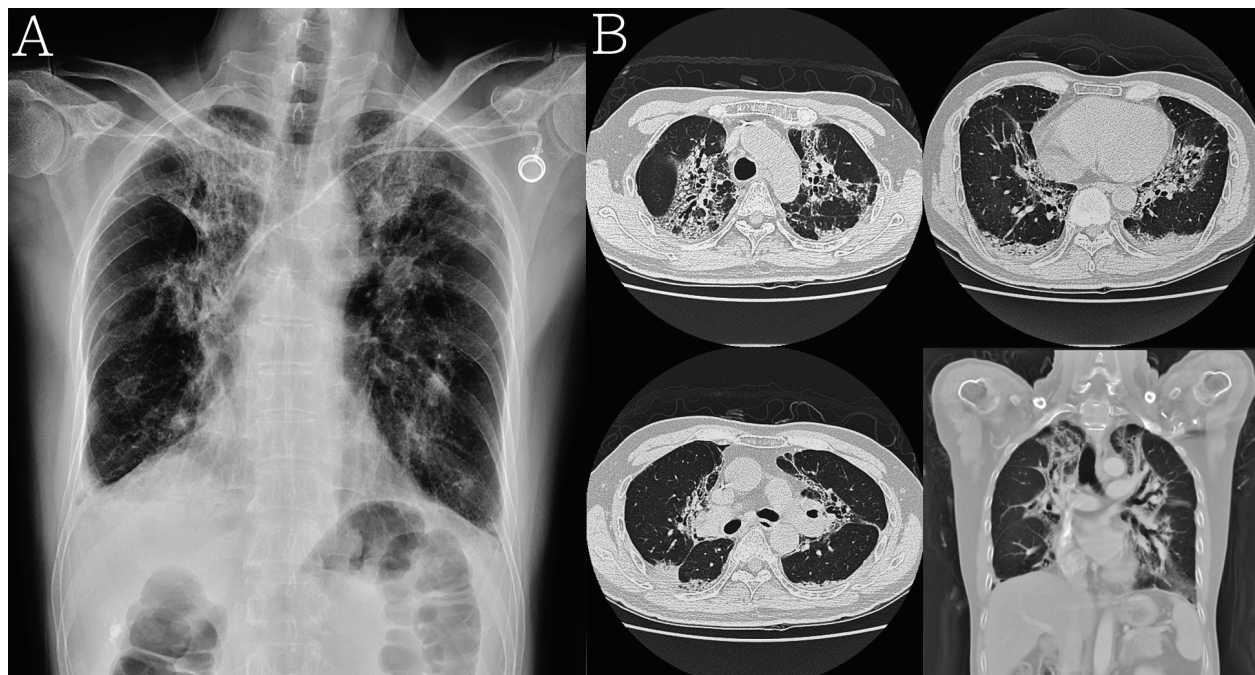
(A) Chest radiography showing a radiopaque area with volume reduction of upper lungs. (B) Computed tomography of the chest showing reticulation, traction bronchiectasis and volume loss in the upper lobes and perihilar regions, suggestive of pulmonary fibrosis.
